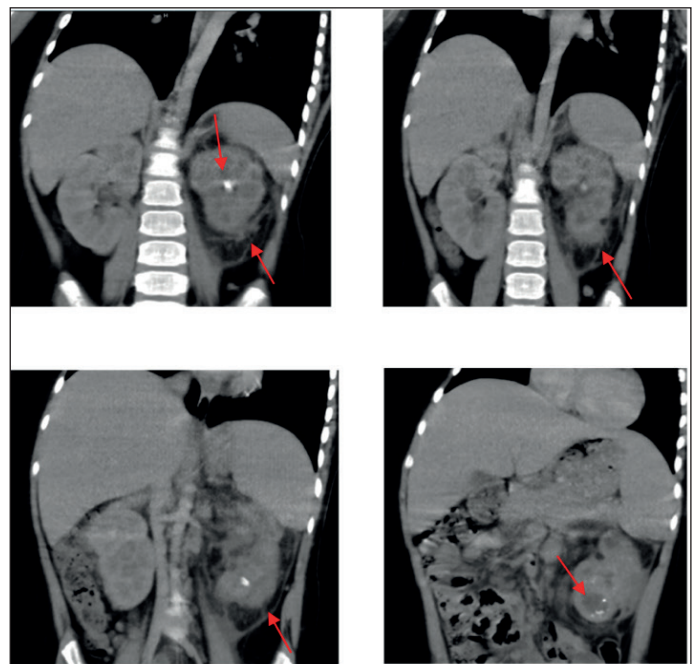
Contrast-enhanced abdominal computed tomography showing multiloculated appearance, ectasia, stones in the collecting system and heterogeneous pararenal area of the left kidney
